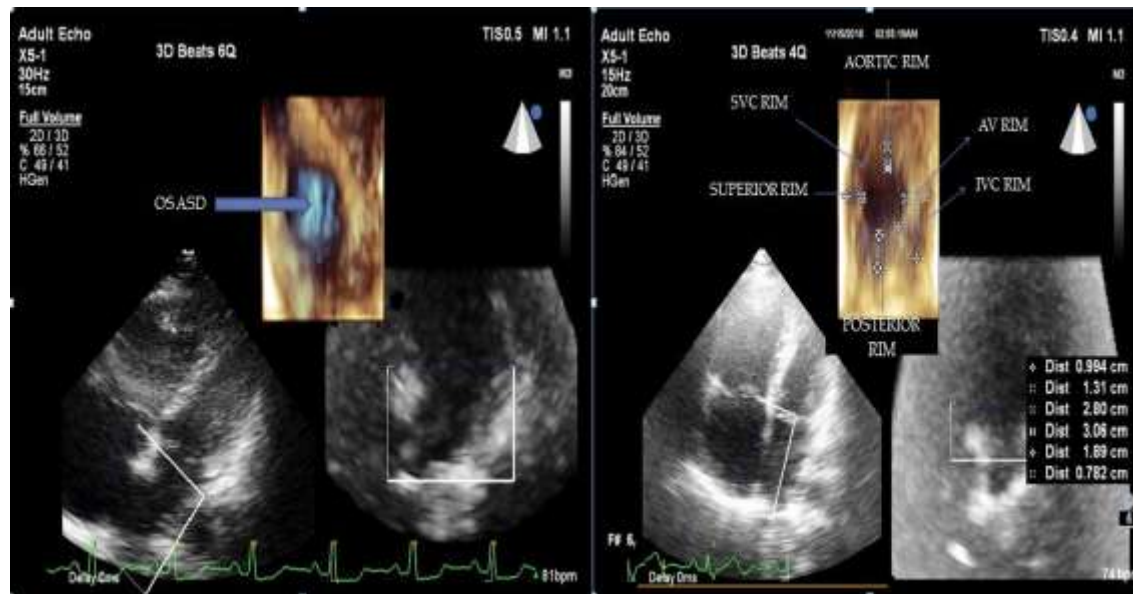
RA en face views on cropping full volume 3D data acquired by Apical 4 chamber view. On left side: isolated ostium secundum ASD and its surrounding structures; on right side: OS ASD with its rims as shown by arrows.
